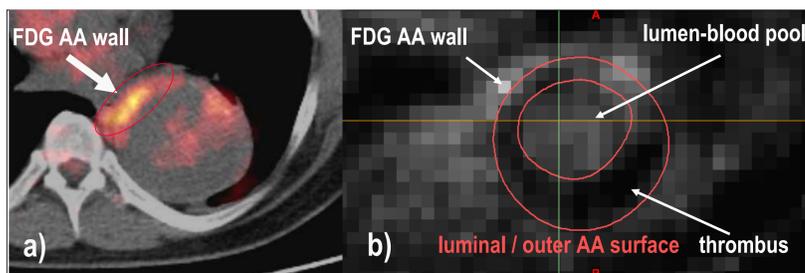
TAA 61J ♂ a) conventional FDG-PET/CT transversal fusion (ROI: SUV_{max} : 4.8 SUV_{mean} : 3.2) b) multiplanar alignment of segmented and reconstructed AA geometry with outer AA wall, thrombus and lumen to FDG-PET cloud signal data set.
